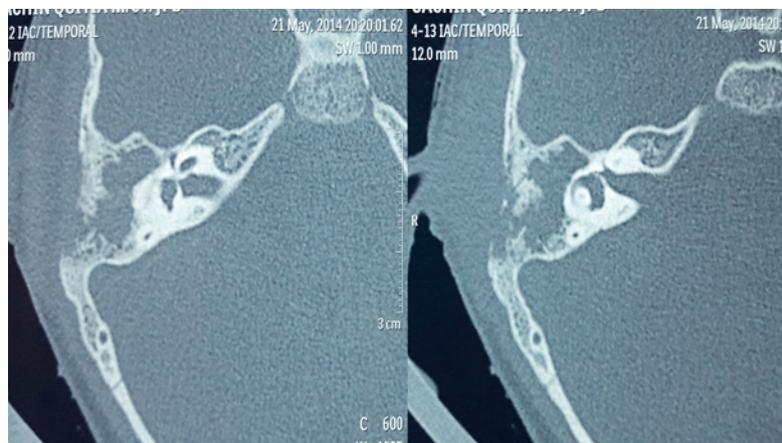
HRCT Temporal bone showing erosion of lateral mastoid cortex causing post-auricular abscess.
